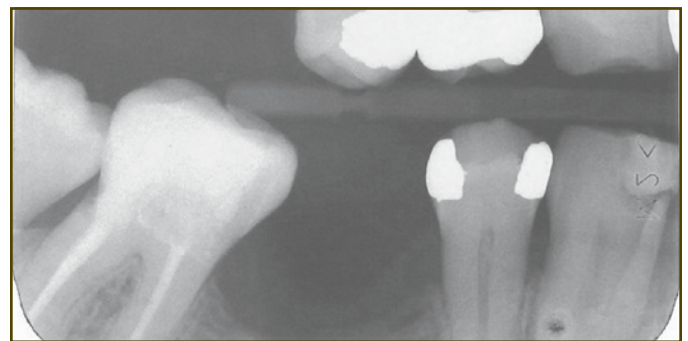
photo and radiograph depicting the knife-edge alveolar ridge and the lack of supporting bone for an implant.
